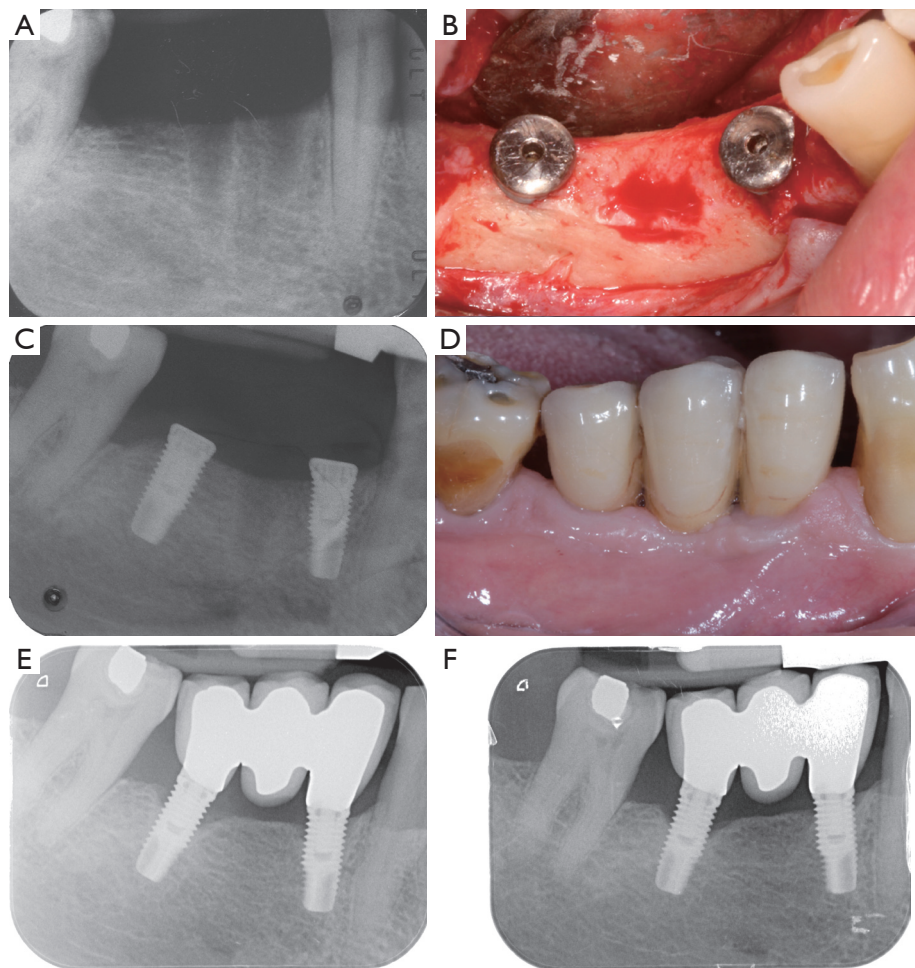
Initial marginal bone loss on different implants placed in the same patient. (A) A alveolar ridge 4 months after tooth extraction. (B) Intra-surgical image showing implant placed in native bone (A) [2009]. (C) Post-operative X-ray. (D) Final restoration delivery [2009]. (E) 1 year [2010] follow-up radiographs showing initial marginal bone loss. (F) 8 years follow-up showed [2017] stable bone loss despite the initial marginal bone loss.
